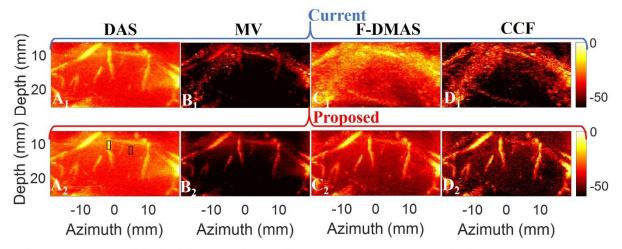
In vivo* myocardial blood flow at early diastole without contrast agents. A_1 , B_1 , C_1 , and D_1 : ultrasound angiography images obtained by existing methods with clutter filtering of beamformed data from DAS, MV, F-DMAS, and CCF, A_2 , B_2 , C_2 , and D_2 : ultrasound angiography images via our proposed scheme with tissue echoes filtering (TEF) of pre-beamformed data. Note that DAS denotes Delay-and-Sum, MV denotes Minimum Variance, F-DMAS is Filtered Delay Multiply and Sum, and CCF refers to Cross-coherence Factor.
